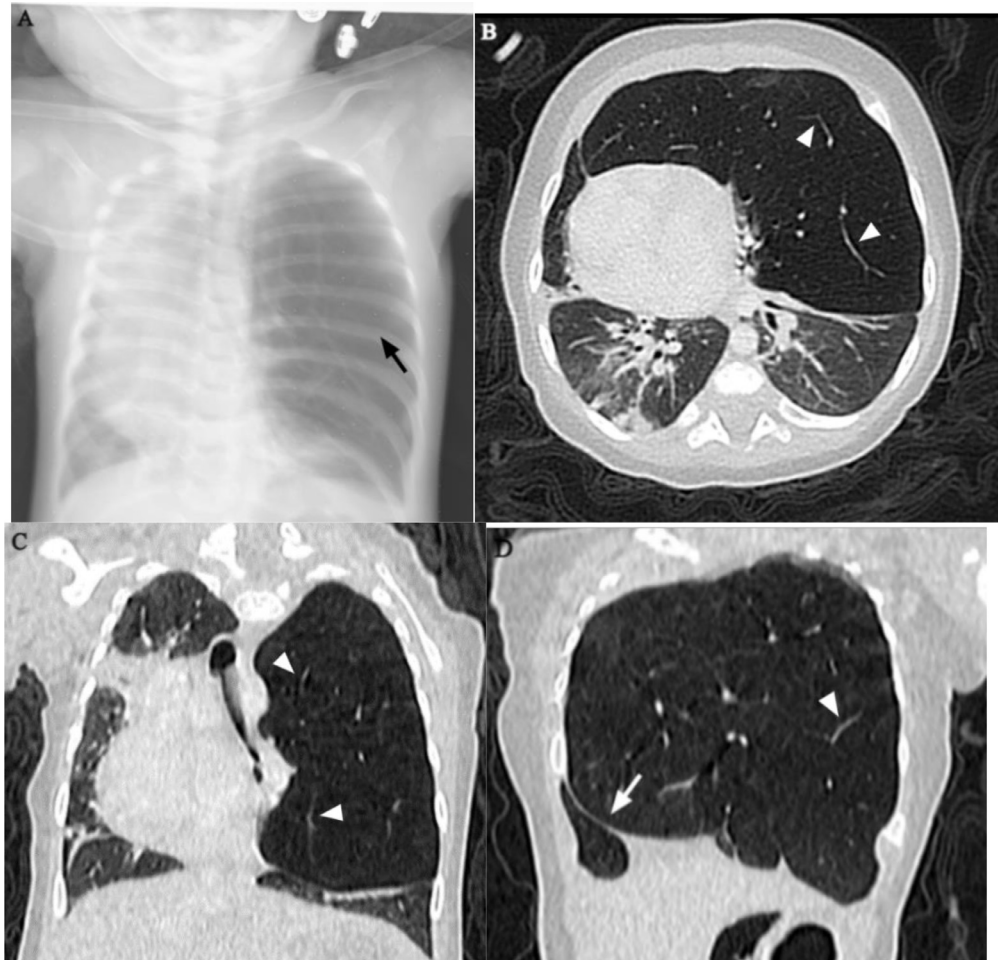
Initial supine chest radiograph (A) shows markedly hyperlucent and hyper inflated left upper and mid lung regions with compressive atelectasis inferiorly and marked right ward mediastinal shift (arrow). Axial (B), and consecutive posterior (C) and anterior (D) coronal sections of chest CT in lung window show severe hyperinflation of the LUL with decreased vasculature (white arrowheads in B-D). On the coronal images, marked right ward tracheal and mediastinal shift is also noted with associated mass effect on the right lung. The arrow (in D) points to severely shifted anterior junctional line.
